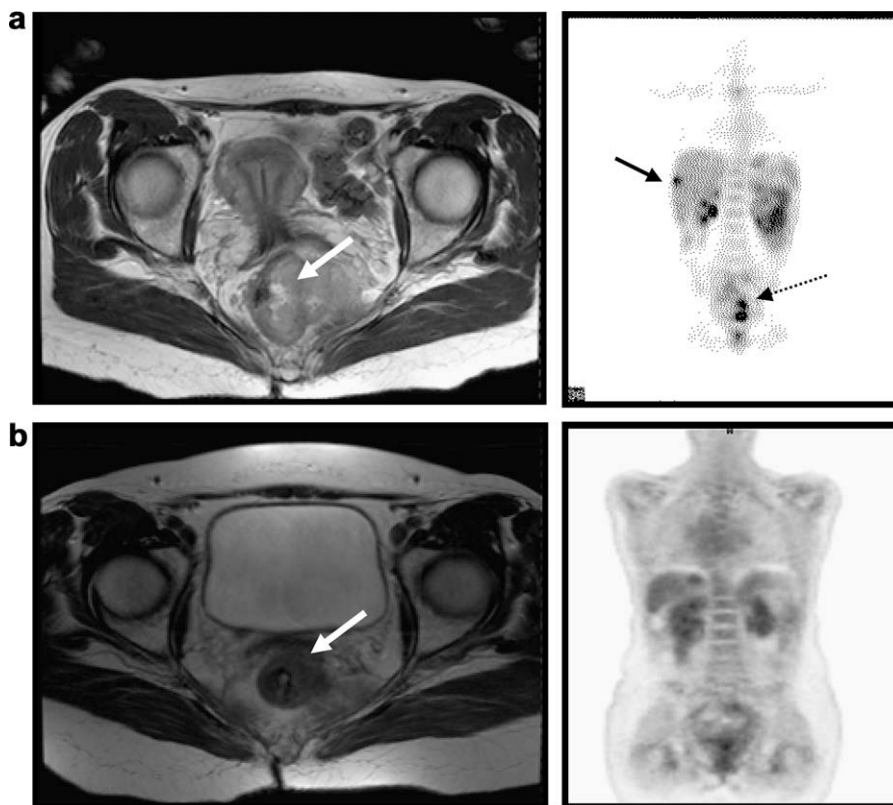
Staging MR and PET images (a) and follow-up MRI and PET (b) 12 months later shows good reduction in the size of the rectal primary (white arrow). Although there is still some residual thickening, PET scan shows that pre-treatment rectal activity (dashed black arrow) has resolved confirming complete response. Also of note, FDG uptake in the liver (solid black arrow) has also disappeared after liver resection.
